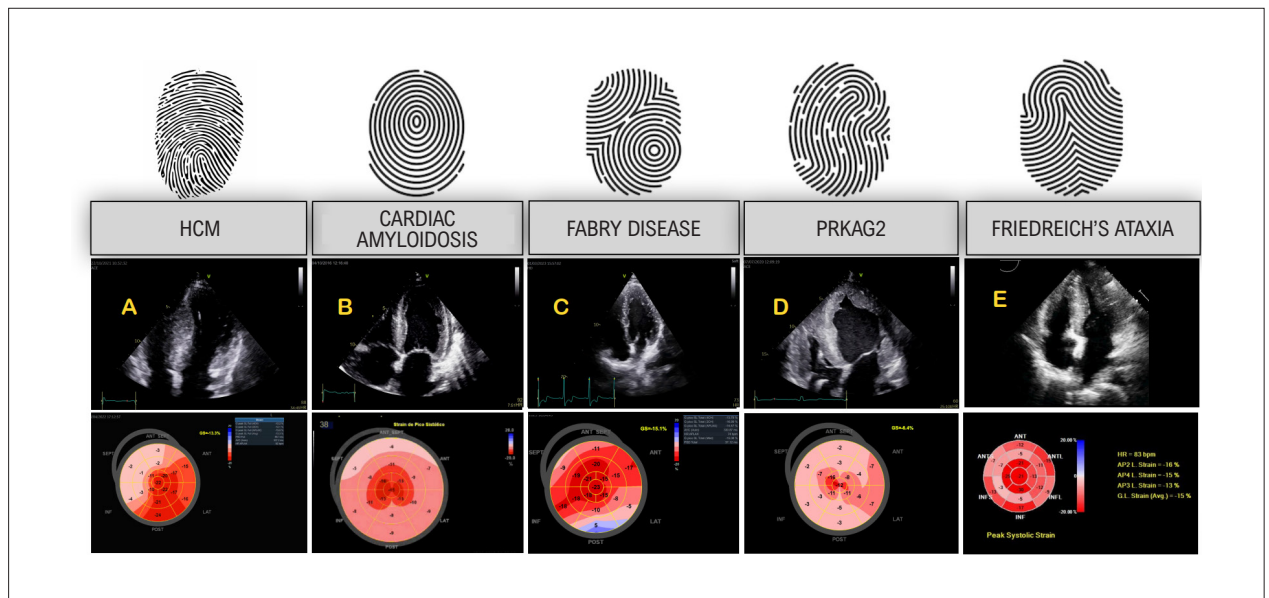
Longitudinal strain patterns in left ventricular (LV) hypertrophic phenotype (bulls-eye parametric display). A) Hypertrophic cardiomyopathy (HCM) showing regional deformation alterations according to the distribution of hypertrophy (in this case, a septal asymmetric HCM), B) Cardiac amyloidosis, with a pattern of “apical sparing,” an echocardiographic red flag for its diagnosis, C) Fabry disease, with typical alteration of deformation in basal anterolateral wall, D) PRKAG2 cardiomyopathy, with massive biventricular hypertrophy in this case, with marked global alteration in GLS showing diffuse pattern, E) Friedreich’s ataxia, with concentric LV hypertrophy, showing alteration of deformation mainly in basal and medial segments, highlighting that “relative apical sparing” is not specific for the diagnosis of CA (this case: courtesy - Dr. Thiago Santos Rosa - Brazil).
